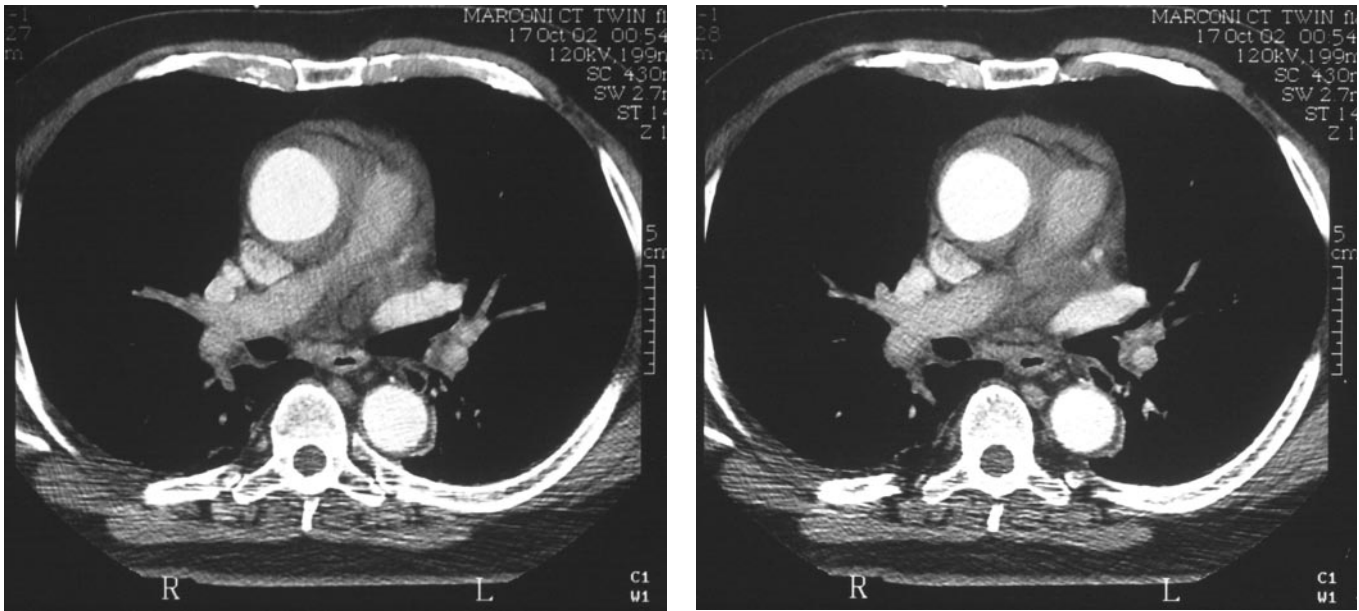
Contrast-enhanced computed tomographic images fail to demonstrate membranous aortic flap.
